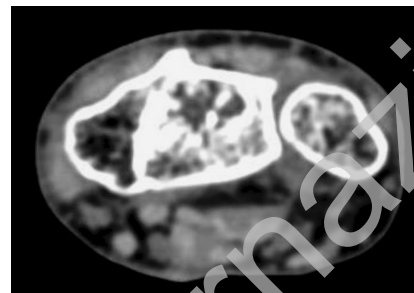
Follow-up radiograph after 90 days of treatment.
